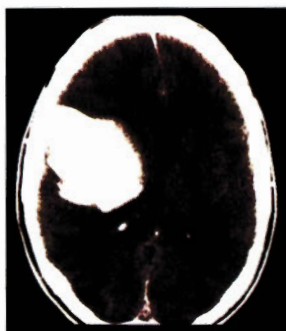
CT of acute intracerebral hematoma
